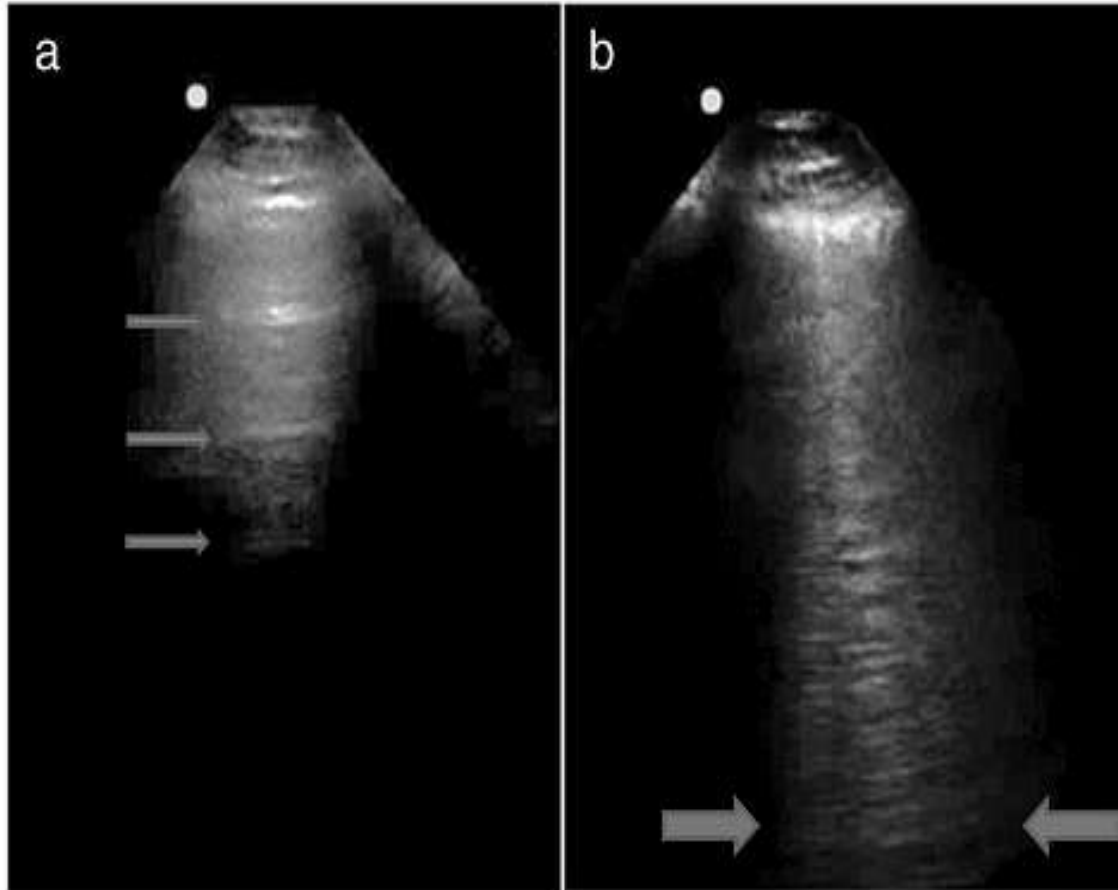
a "A lines": distinct horizontal reflections in a patient with normal lungs (*arrows*). b "B lines": three vertical lines in a single frame extending from the pleura to the bottom of the screen in a patient with ultrasound interstitial syndrome (*between arrows*)
